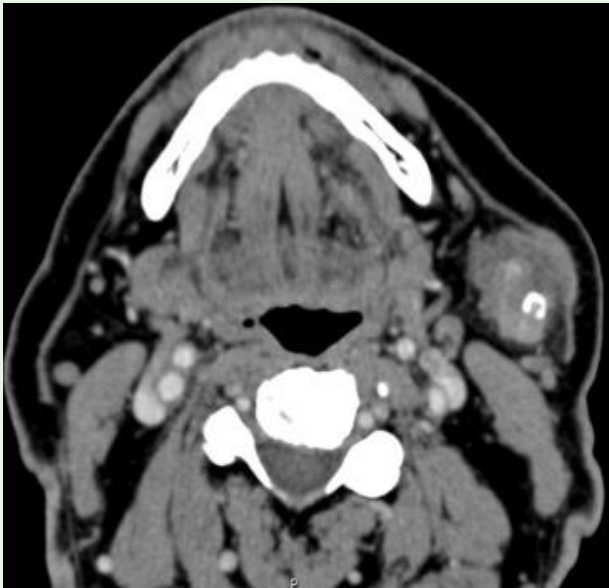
Axial CT scan showing left tail of parotid mass with invasion of the overlying musculoaponeurotic system and intralesional calcification.
